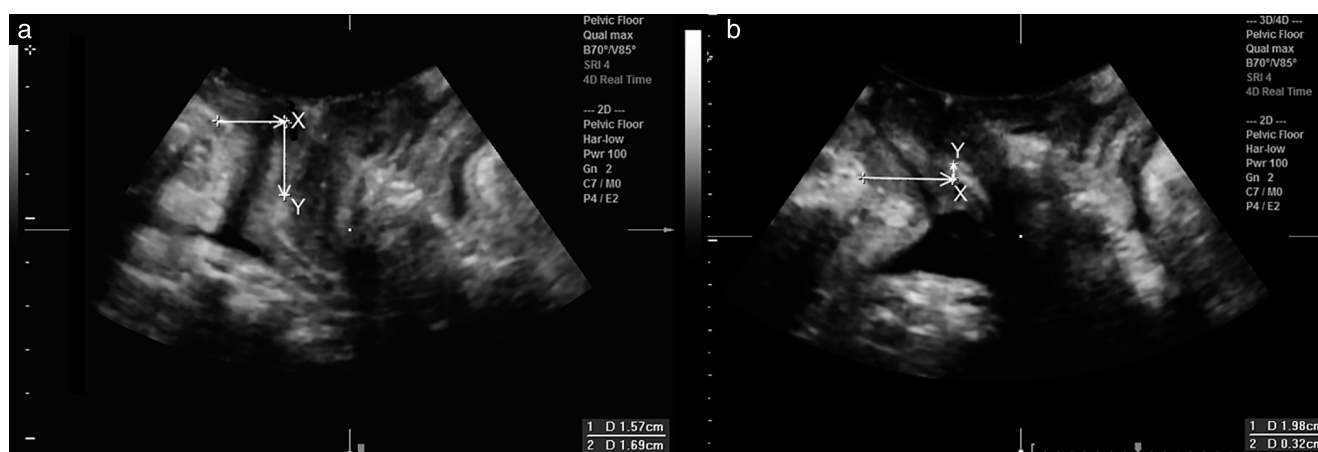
Measurement of mesh mobility by four-dimensional transperineal ultrasound at rest (a) and on Valsalva (b), using the formula: $\sqrt{[(X_{\text{Valsalva}} - X_{\text{rest}})^2 + (Y_{\text{Valsalva}} - Y_{\text{rest}})^2]}$, where X is horizontal distance and Y is vertical distance of mesh from symphysis pubis.
